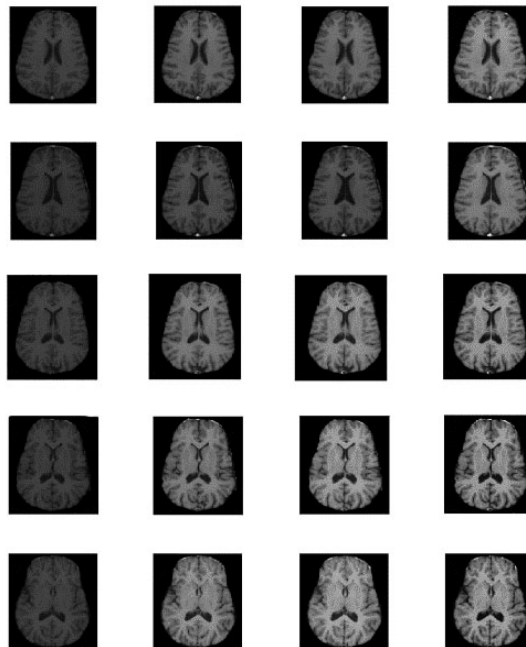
T1-weighted original images (first column) and the images enhanced using WNM-1, WNM-2 and the polynomial based method.
